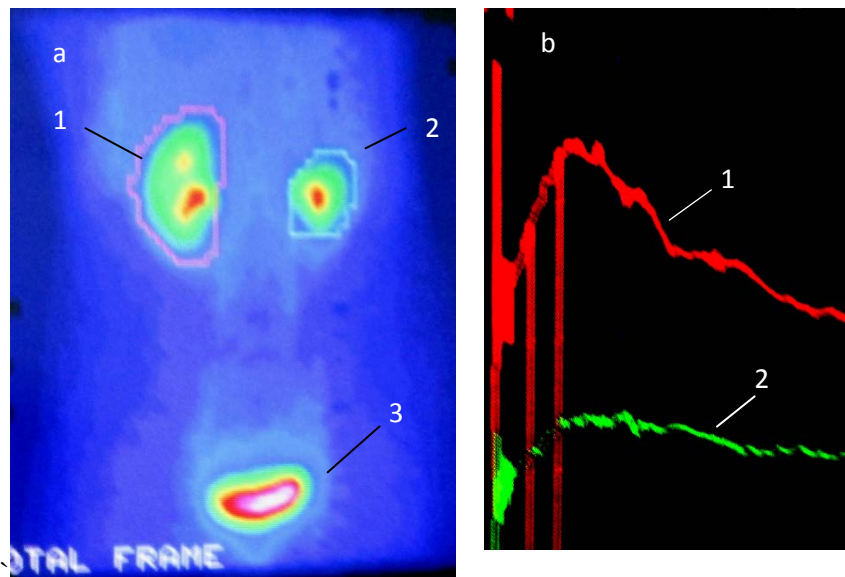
Dynamic nephroscintigraphy (research of glomerular filtration with  $^{99m}\text{Tc}$ -DTPA (the pharmacological moiety is a pentavalent chelating agent): a) distribution of radiopharmaceutical in kidneys due glomerular filtration. 1- left kidney, 2- right kidney, 3 – urinary bladder. Note sharp decrease size of right kidney; b) histogram: curves reflecting level of a filtration in the left kidney (1) and in the right kidney (2). Hypoplastic kidney on the right with its hypofunction.
